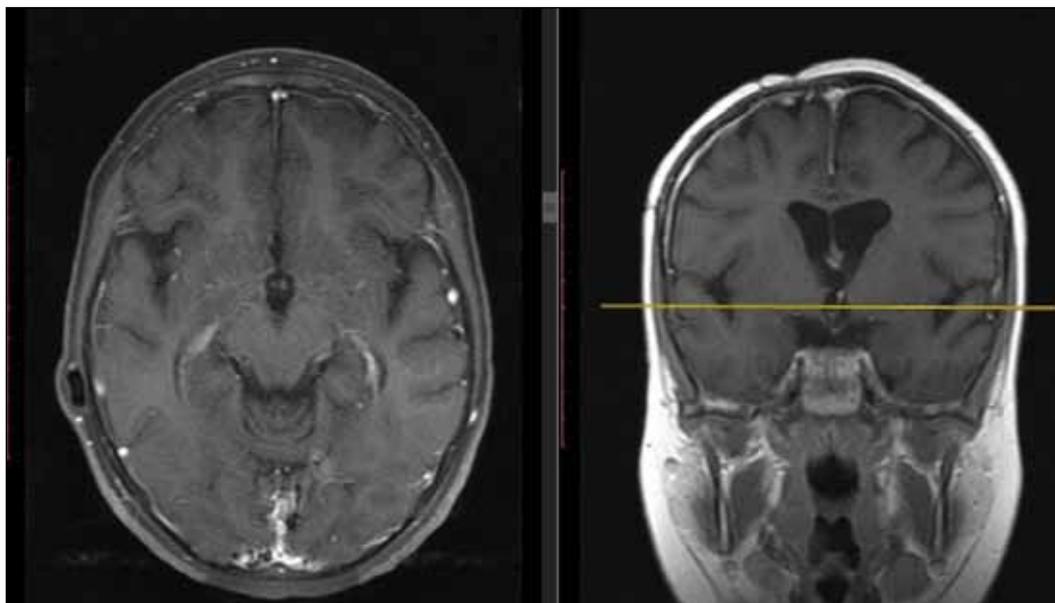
Postoperative 27th month axial (left) and coronal (right) MRI; T1-weighted images that demonstrated postoperative changes without recurrence or residual tumor.
